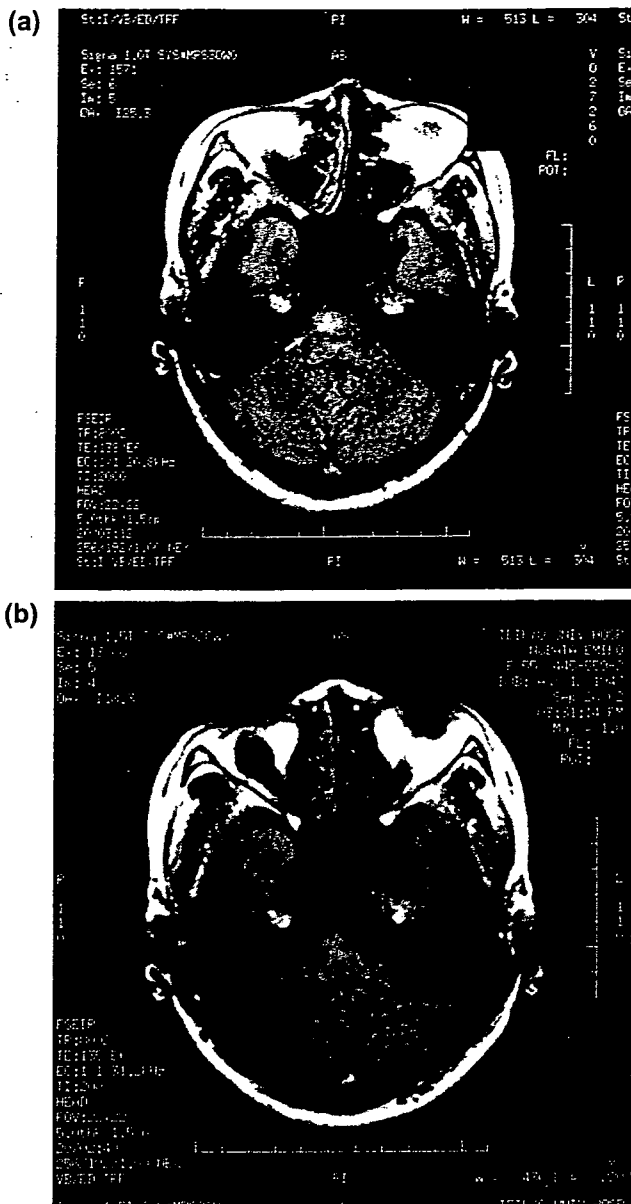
Axial fluid attenuated inversion recovery (FLAIR) brain MRI of a patient with acute type neuro-Behçet's syndrome at acute phase (a), and remission phase (b).
